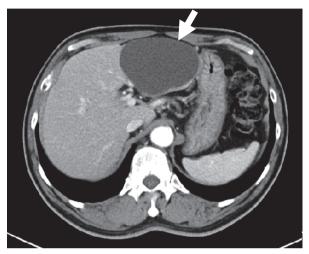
Abdominal computed tomography revealed a 10.8 x 8.9 x 6.3 cm cystic lesion at left lobe of the liver (white thick arrow).
